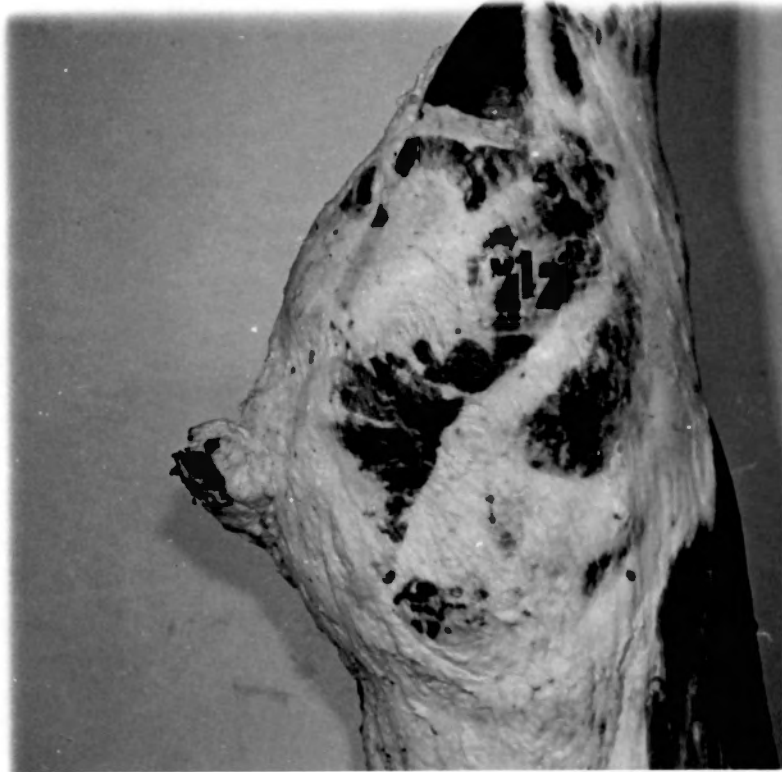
Locations of the four ultrasonic measurements on the round are shown as they appeared on the carcass.
